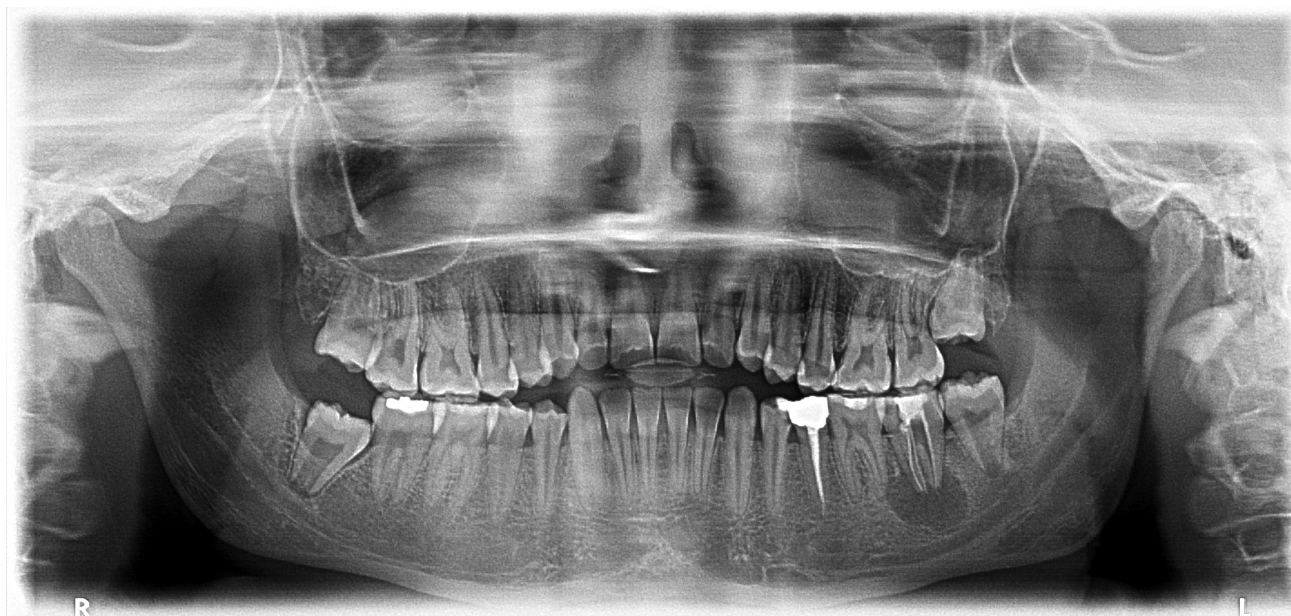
Diagnostic panoramic radiograph
